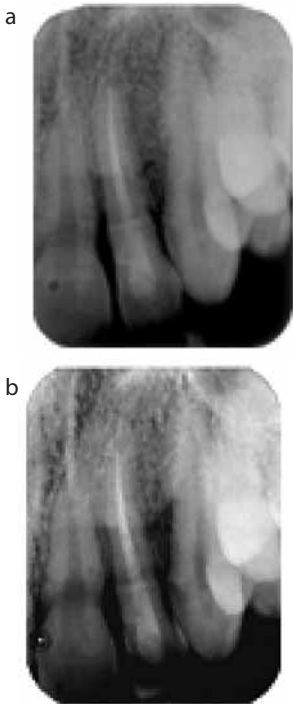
Periapical radiograph (a) taken at insertion of post and (b) periapical taken 6 months after treatment.
